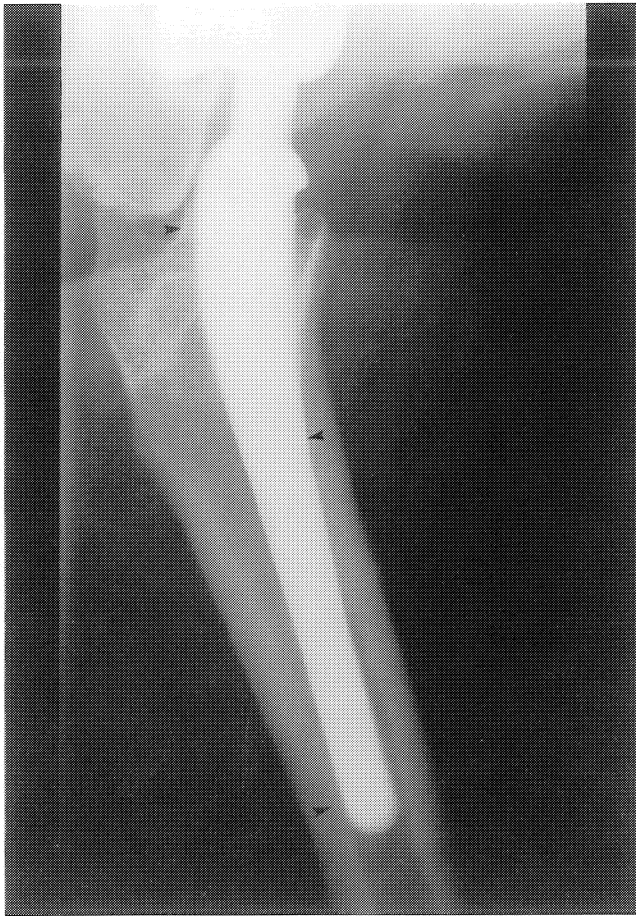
Lateral radiograph demonstrating three-point cortical contact.
